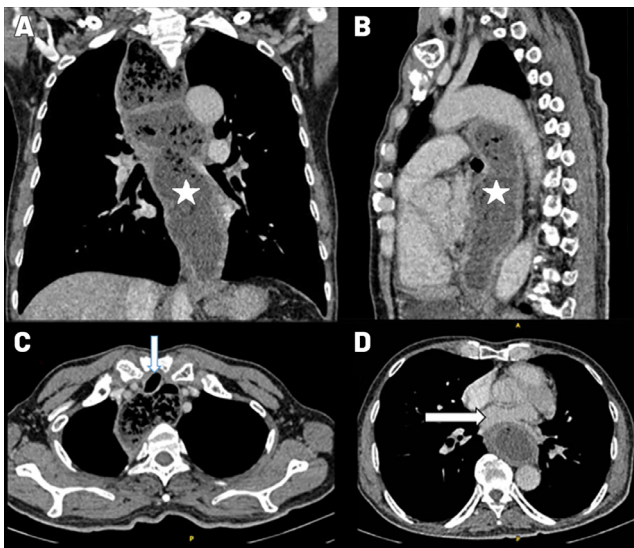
(A and B) Coronal and sagittal CT postcontrast images revealing a dilated esophagus (asterisk) containing food residue. Axial images showed compressed trachea (arrow in C) and left atrium (arrow in D), which resulted from a dilated esophagus filled with food residue.
